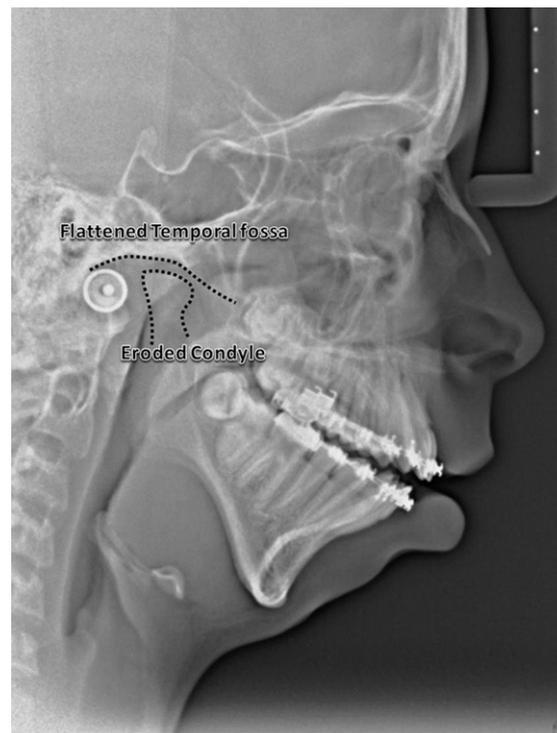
The characteristic cephalometric radiographic presentation of juvenile idiopathic arthritis shows flattening of the anterosuperior aspect of the condyles and irregular destruction of the temporal fossa, seen as flattening of the fossa.
